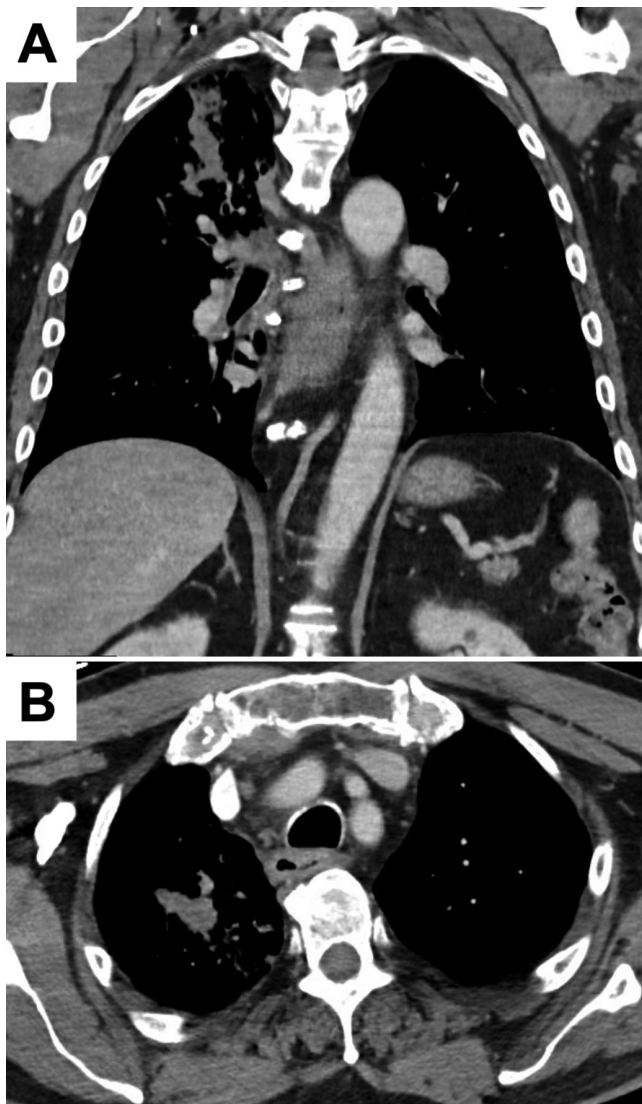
Contrast-enhanced CT images of the chest showing the lung lesion. Coronal (A) and axial (B) contrast-enhanced CT images demonstrating a right lung upper lobe mass-like consolidation with irregular borders and internal heterogeneity involving the mediastinum, highly suspicious for primary lung malignancy.
